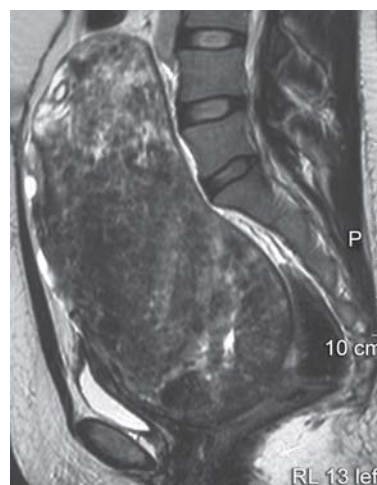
MRI sagittal view showing large fibroid uterus
